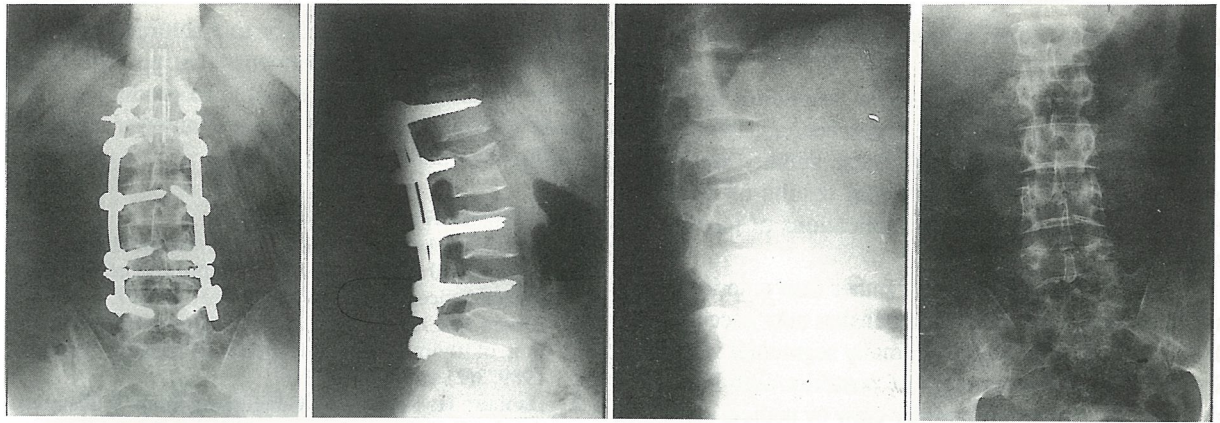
Preoperative and postoperative anteroposterior and lateral x-rays of a fracture patient.
